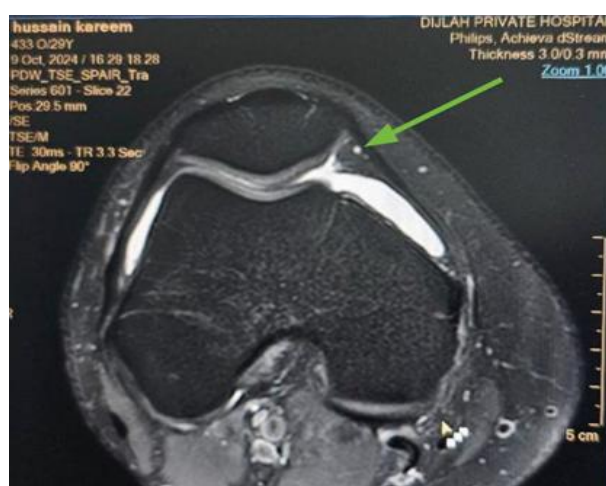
MRI, axial view of Attenuated MPFL.
